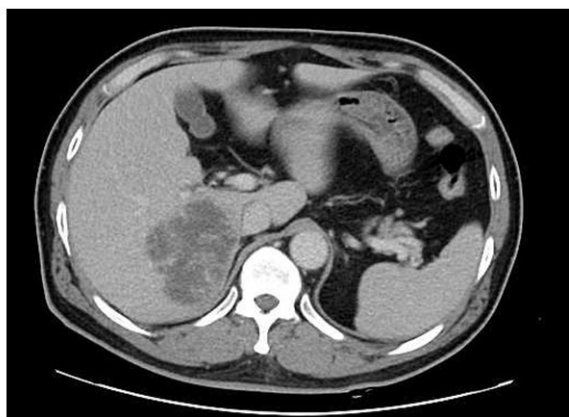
Pancreas & Biliary CT
